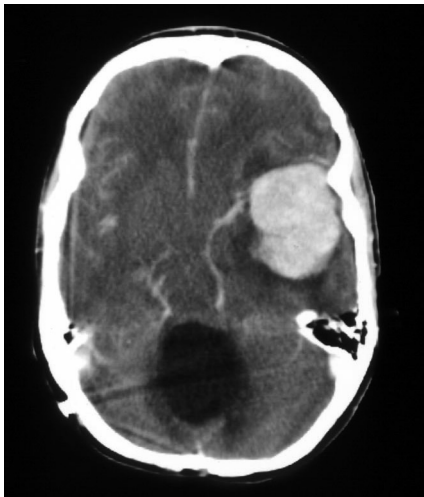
Brain CT with contrast enhancement showing a large space-occupying lesion in the left temporal region with oedema and midline shift. There is a defect in the cerebellar region due to surgical removal of an ependymoma of the fourth ventricle.
